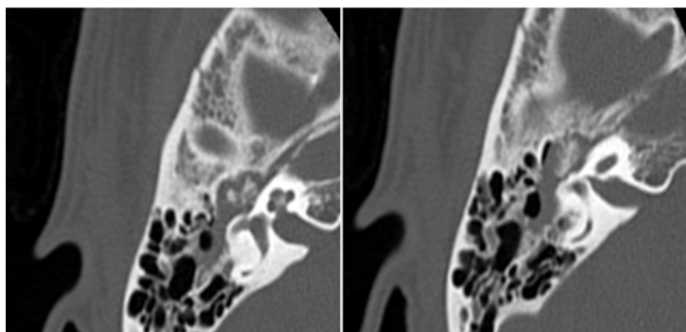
Right Temporal bone fracture Axial HRCT image shows Linear non displaced fracture is seen involving right squamous temporal bone.
